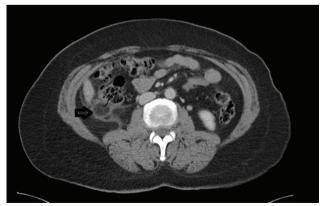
Contrast-enhanced axial computed tomography images show well-defined focus of hypodense fat tissue (black arrow), thickened peritoneal ring. and periappendageal fat stranding (white arrow).
